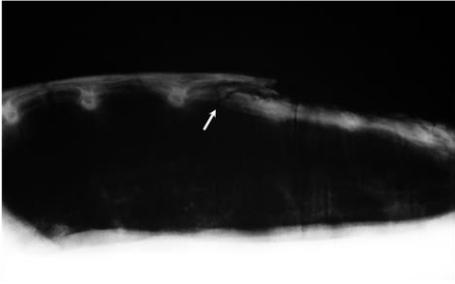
Radiographic images of the previous case after 3 months of therapy show the almost total resolution of pneumonia.
